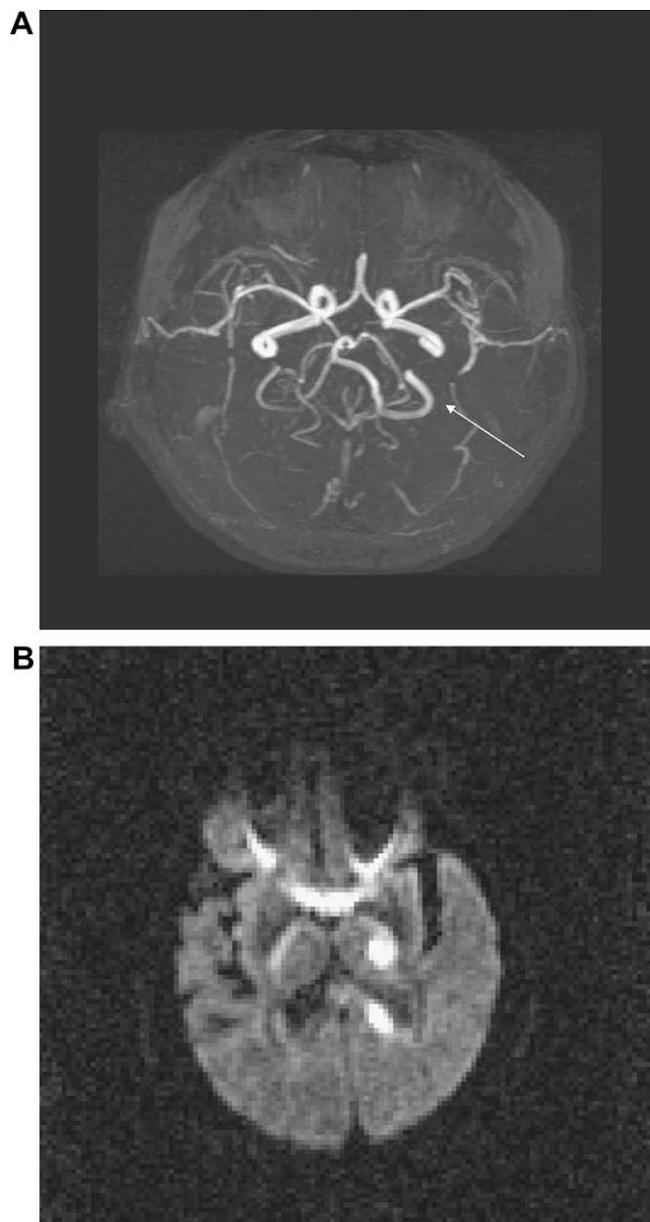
(A) Cerebral magnetic resonance angiogram of a 53-year-old male with a 10-year history of hypertension, who presented with acute onset of right hemiparesis, hemianesthesia and homonymous hemianopsia. (B) The corresponding MRI (diffusion-weighted imaging) disclosed multifocal hyperintense lesions involving the left thalamus and occipital lobe; which fulfilled the posterior choroidal artery occlusion¹¹ and TOAST subtype criteria for small-artery atherosclerosis. This image also revealed agenesis of the left posterior communicating artery (arrow). (TOAST = Trial of ORG 10172 in Acute Stroke Treatment).
